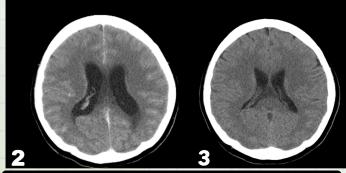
Cranial CT Scan Taken March 2025 showing hydrocephalus with repeat CT taken after 4 months showing markedly decreased hydrocephalus (Figure 3)
